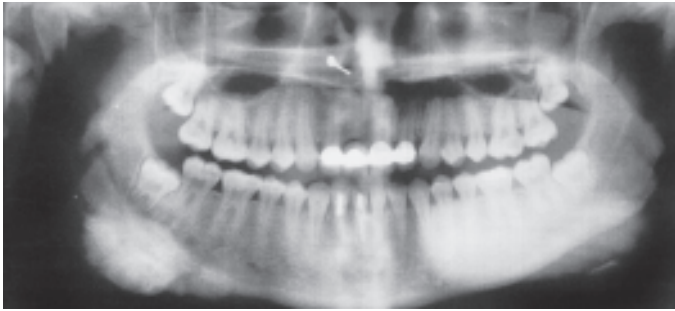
Radiograph showing radiopacity and sunray appearance in osteosarcoma
